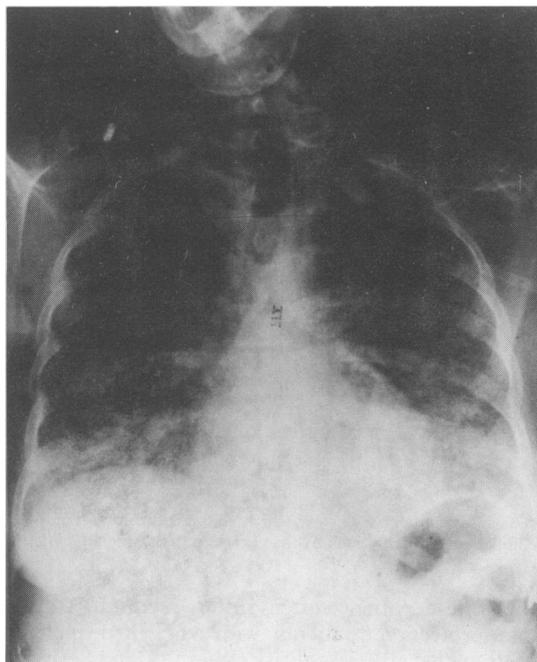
Chest X-ray, P/A projection, Case 2, 4th hospital day. Diffuse patchy interstitial infiltrates are noted.
